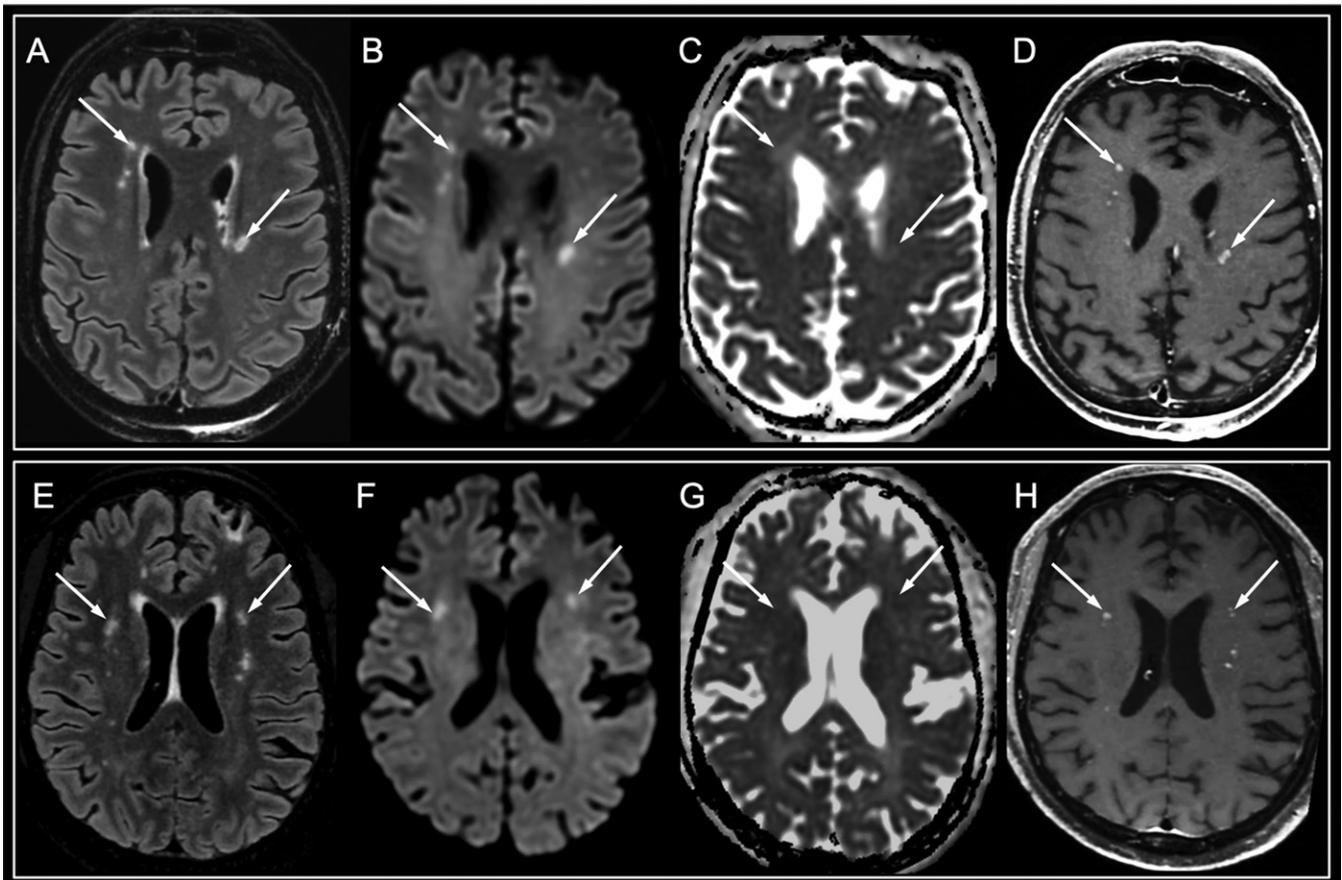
White matter–enhancing lesions in, A–D, a 50-year-old man with a history of kidney transplantation and, E–H, a 50-year-old man in the intensive care unit with type 2 diabetes. These patients experienced late awakening after withdrawal of sedation after 39 and 65 days, respectively, of intensive care for severe hypoxic severe acute respiratory syndrome coronavirus 2–associated pneumonia complicated by severe acute respiratory syndrome. Both patients progressively recovered consciousness and were able to respond to orders. A similar imaging pattern as that in Figure 3 was seen but with fewer white matter lesions appearing hyperintense on fluid-attenuated inversion recovery images (arrows in A and E) and diffusion-weighted images (arrows in B and F), without apparent diffusion coefficient decrease (arrows in C and G), and with perivascular enhancement on postcontrast T1-weighted images (arrows in D and H).
